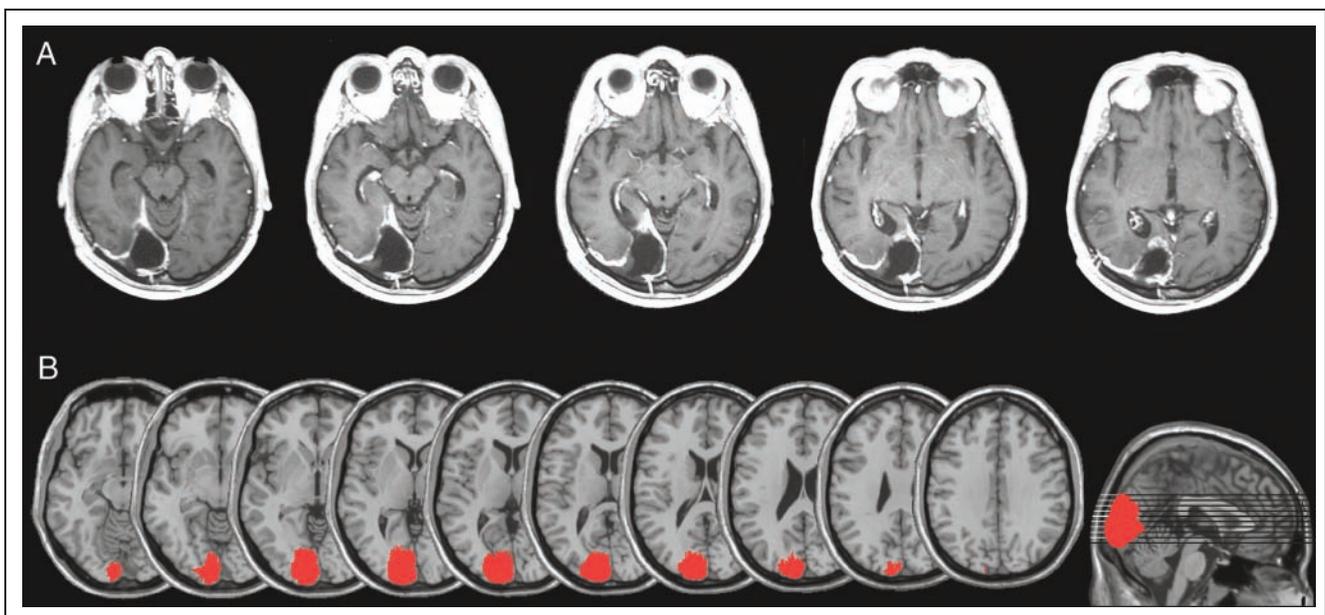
(A) Original MRI scans and (B) reconstruction of the patient’s brain lesion drawn from MRI T1-weighted template (Montreal Neurological Institute) using MRICro software (<http://www.psychology.nottingham.ac.uk/staff/cr1/mricro.html>).
